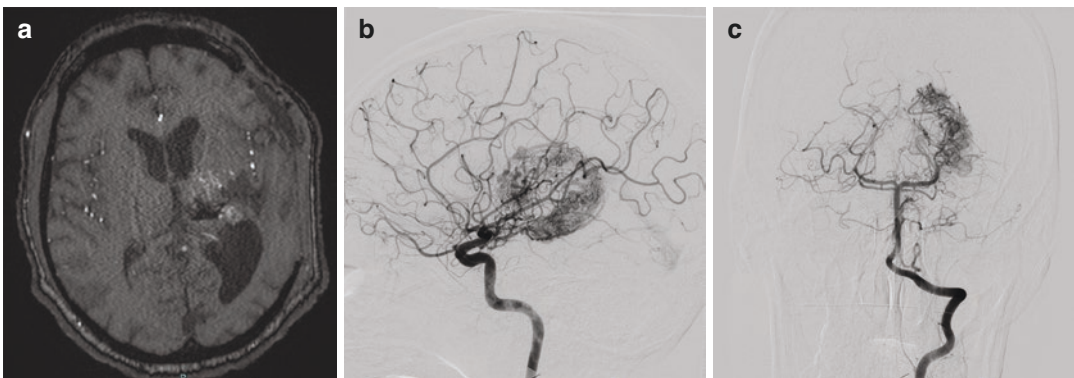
(a) MRI showing a basal ganglia AVM with diffuse nidus, likely a good radiosurgery candidate. (b, c) Conventional angiogram demonstrating the deep-seated AVM
